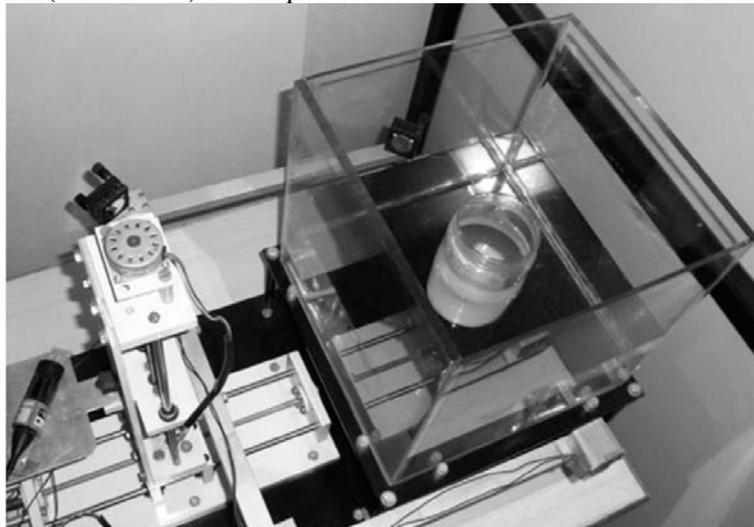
In-house fabricated Laser CT scanner.
